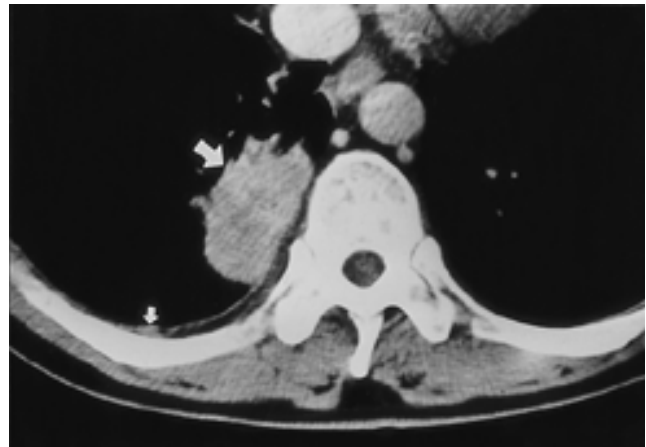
A 38-year-old man with pleural dissemination from adenocarcinoma of the lung. Contrast-enhanced CT scan (10-mm collimation) shows a primary tumor (large arrow), located in the peripheral portion of the right lower lobe, with contiguity to the pleural surface. A plaque-like thickening of the pleura (small arrow), about 3 mm in thickness, is identified on the costal surface. Surgery revealed pleural dissemination that had been overlooked at preoperative CT examination.
